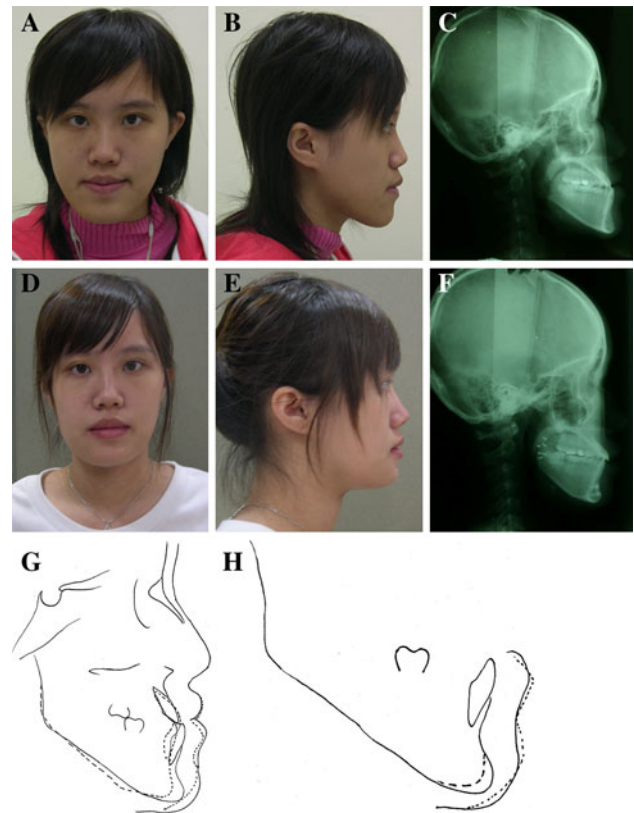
a–c Pretreatment view of a 22-year-old woman who underwent a mandibular setback and vertical chin reduction. d–f Post-treatment view when braces were detached. g–h Superimposition of cephalometric radiograph, registered on cranial base and best fit of mandibular anterior border, to show mandibular movement and genial movement
